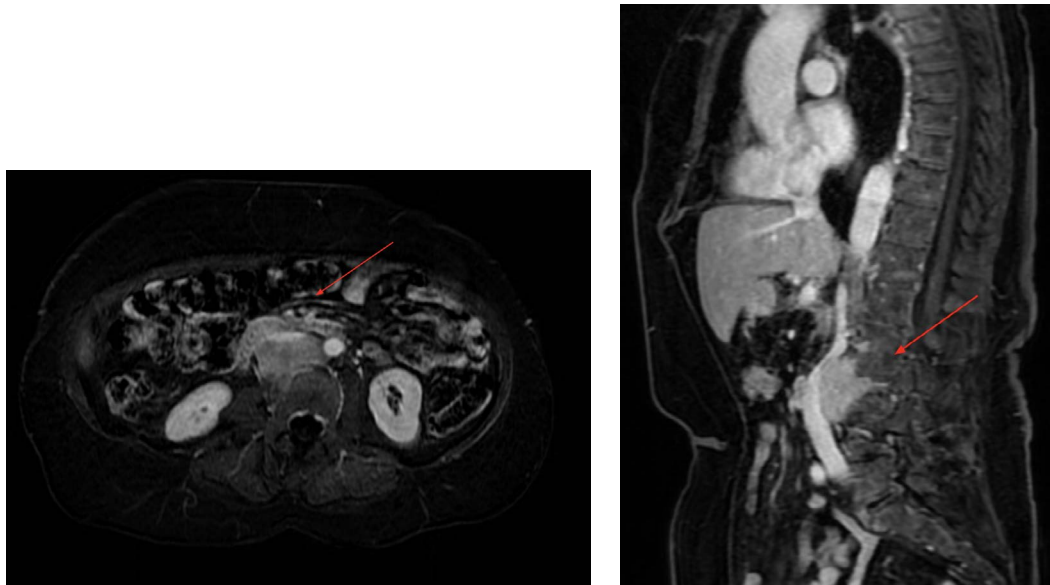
Contrast enhanced MRI images demonstrate a homogeneously enhancing mass corresponding to solitary extramedullary plasmacytoma of the retroperitoneum as indicated by the red arrows.
